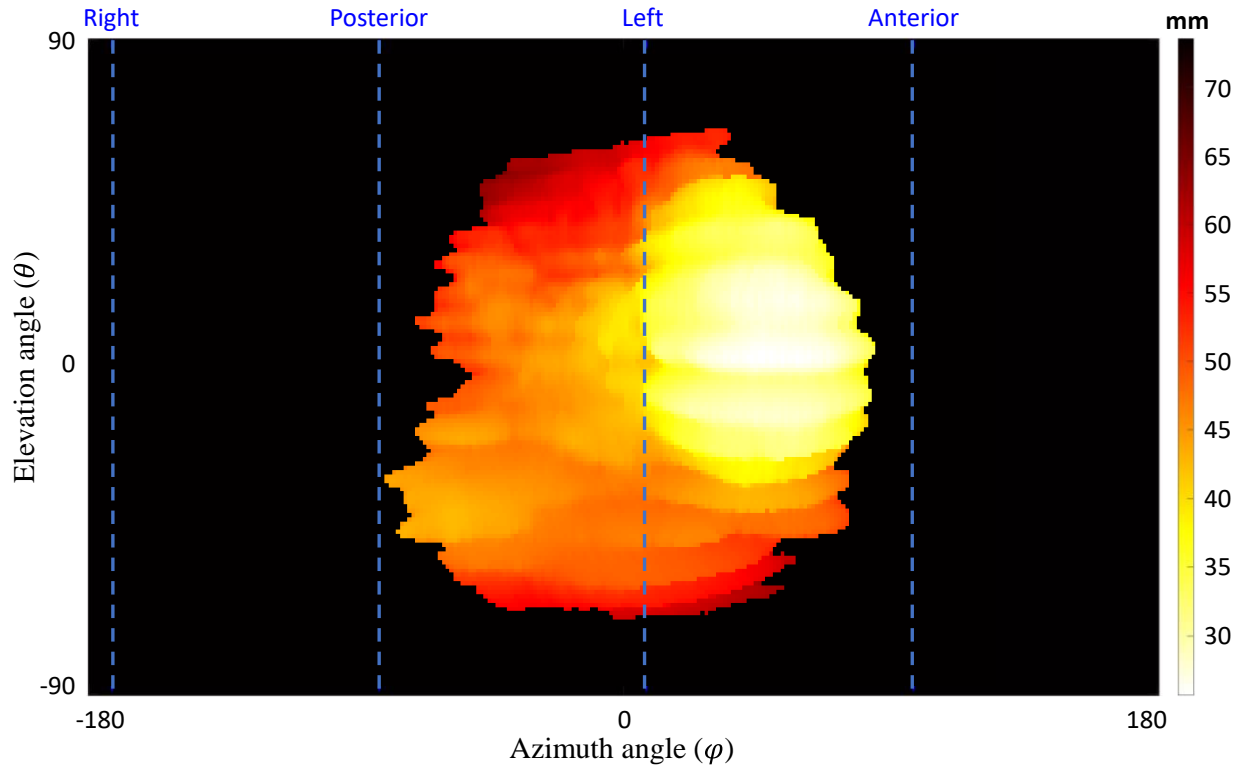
A topographic distance map for the maternal side surface points in a sample case. The dashed lines show the anterior, posterior, right, and left orientations based on the MR imaging axes. The top and bottom of the topography map show the superior and inferior sides, respectively.
